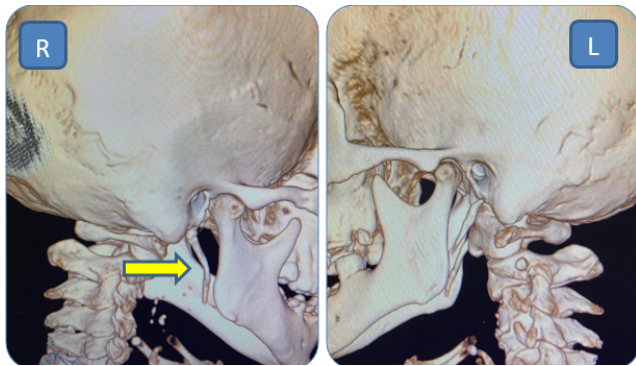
3D CT scan revealing elongated and medially deviating styloid process on the right side.
